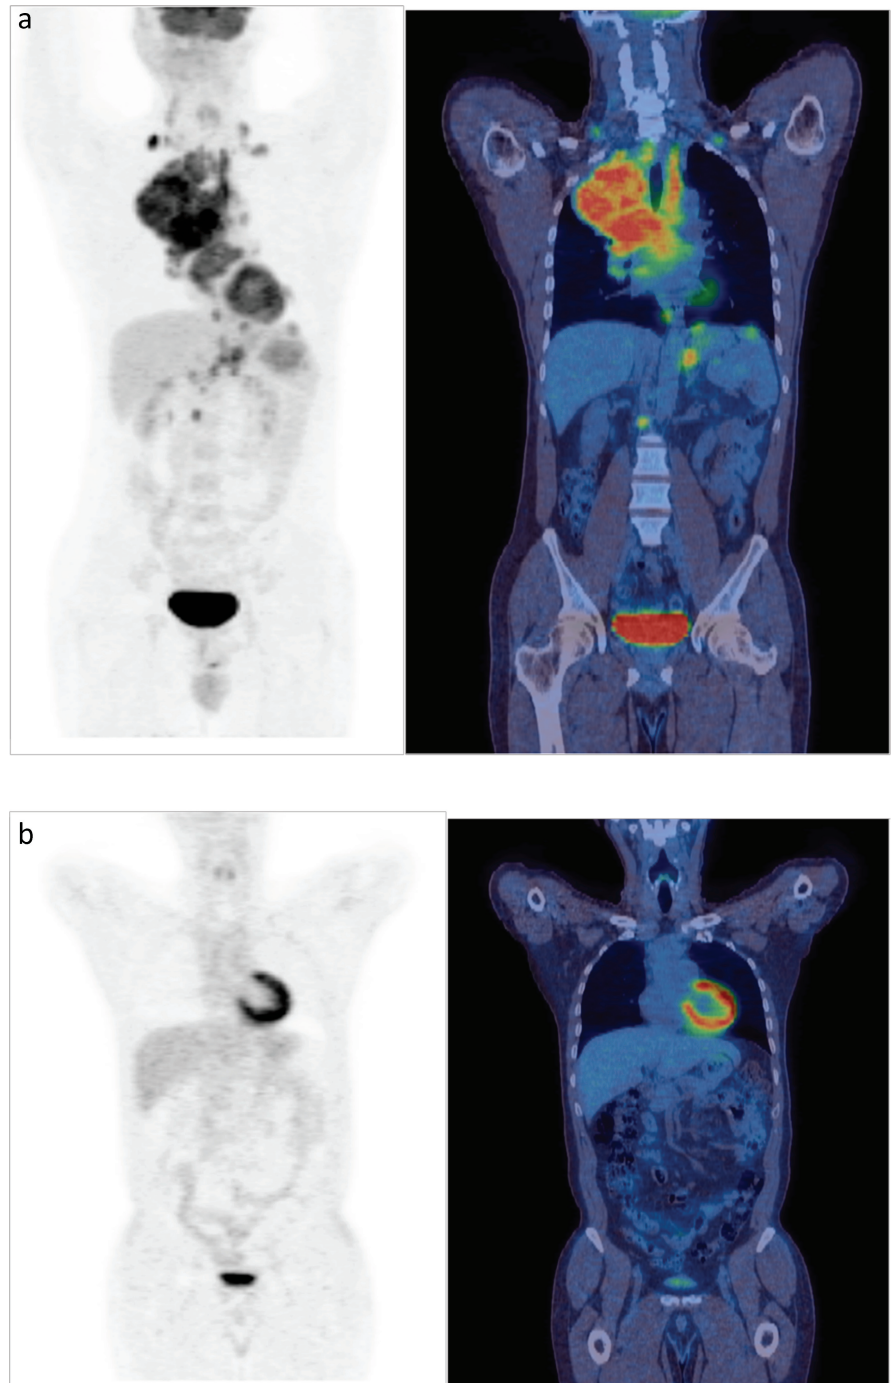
Hodgkin's disease: (a) Coronal images show increased metabolic activity in multiple lymph nodes above and below the diaphragm and a large anterior mediastinal mass. (b) Post-chemotherapy, there is complete resolution of ^{18}F -FDG uptake in lymph nodes and mediastinal mass, in keeping with a complete metabolic response.
